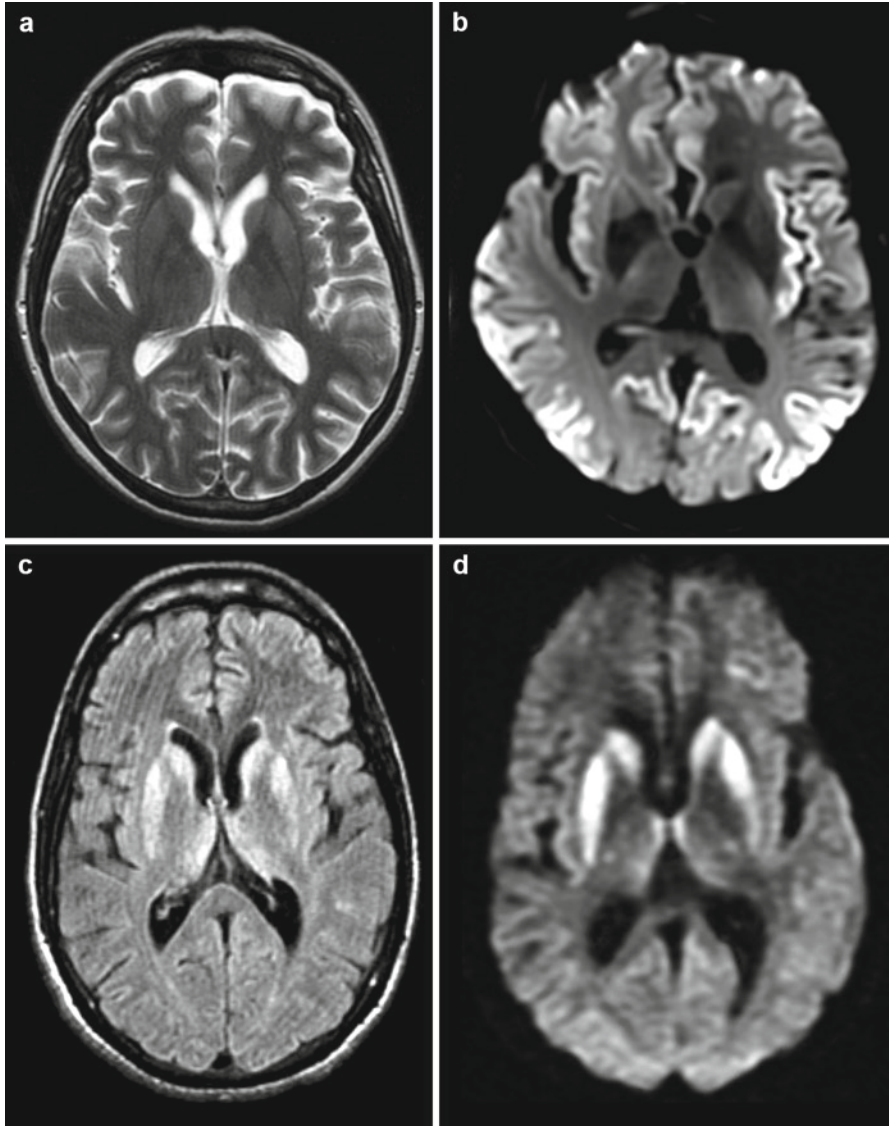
(a) T2-weighted axial MRI in sCJD showing subtlety of increased cortical signal. (b) Diffusion-weighted imaging (DWI) showing cortical ribbon in sCJD. (c) FLAIR images in sCJD. (d) DWI showing high signal in the caudate, putamen, and less so from the thalamus in sCJD. (e) FLAIR images in iCJD showing cortical, caudate, putamen, and thalamic high signal. (f) FLAIR images showing pulvinar sign in vCJD
